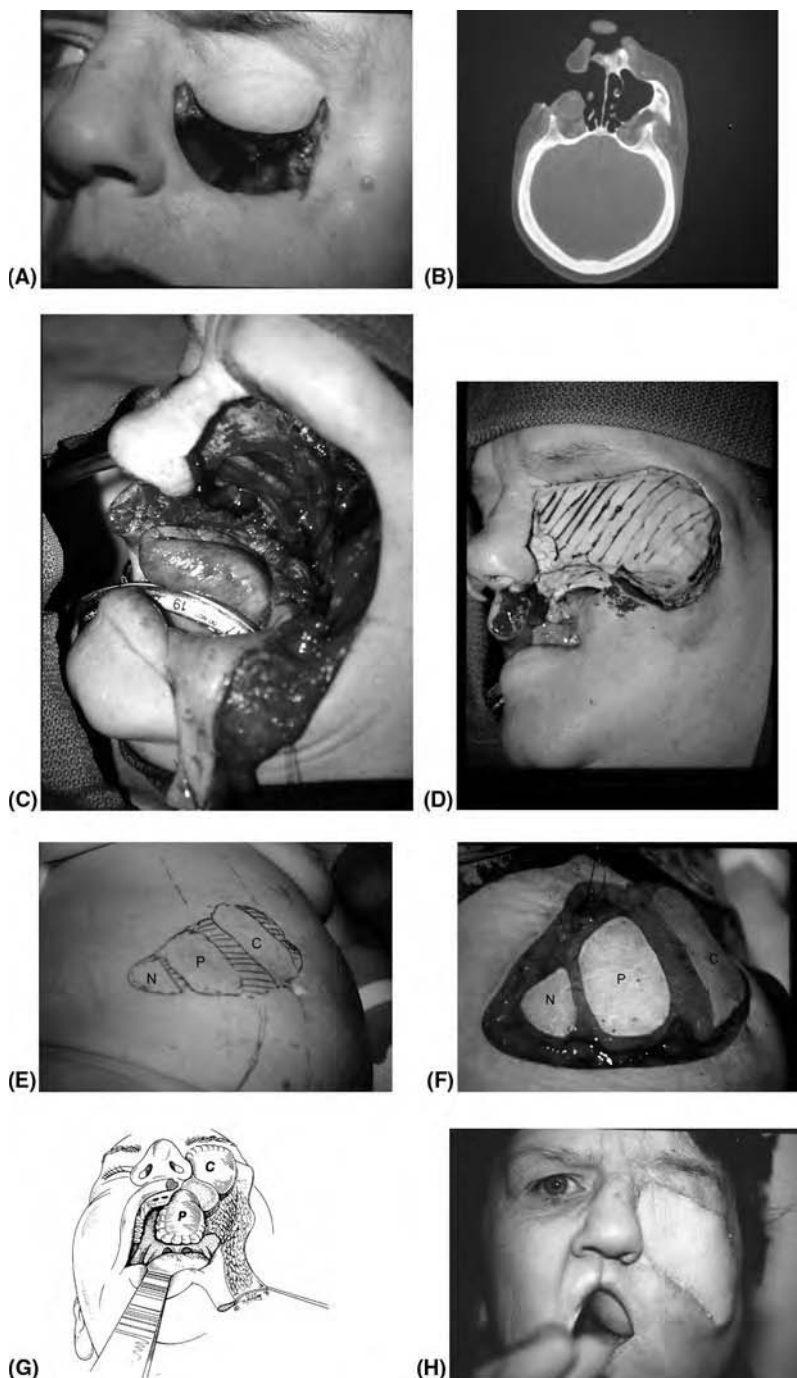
Folded flap, rectus abdominis. (A) A 53-year-old woman with long-standing squamous cell carcinoma of maxillary antrum with erosion forming an oronasocutaneous fistula. (B) Coronal CT scan demonstrating oronasocutaneous fistula. (C) Intraoperative photograph after orbital exenteration and left cheek with discontinuity resection of left nasal cavity, nasal septum, hemimaxilla, and most of palate. (D) Alginate mold in place, epithelial surfaces marked. (E) Two-dimensional flap marked from three-dimensional model of defect in most appropriate orientation on abdomen. (F) The flap is raised and de-epithelialized in situ to provide three epithelial surfaces for reconstruction of nasopharynx (N), palate (P), and cheek (C). (G) Inset of palate and cheek. (H) Three months postoperatively, showing a well-healed, functional, and aesthetically acceptable reconstruction.
